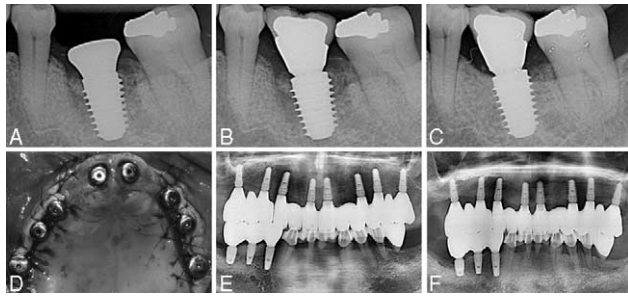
Single implant placed in the mandible and multiple implants placed in the maxilla: (A) a wide-diameter single implant was placed immediately after extraction of a mandibular molar. Insertion torque was 50 N-cm and ISQ value was 77. (B) delivery of the crown 72 h after surgery. ISQ value was 80 at that time. (C) periapical radiograph of the final crown after 1 yr of loading. ISQ was 82 at that time. (D) Intraoperative clinical photograph of 8 implants placed in the maxilla. ISQ values were measured immediately after placement, and 1 week later, (E) panoramic radiograph at the delivery of the final fixed full-arch. (F) panoramic radiograph of the final fixed full arch after 1 year of functional loading. All implants showed stable crestal bone level without clinical symptoms or biological complications. ISQ, implant stability quotient.
